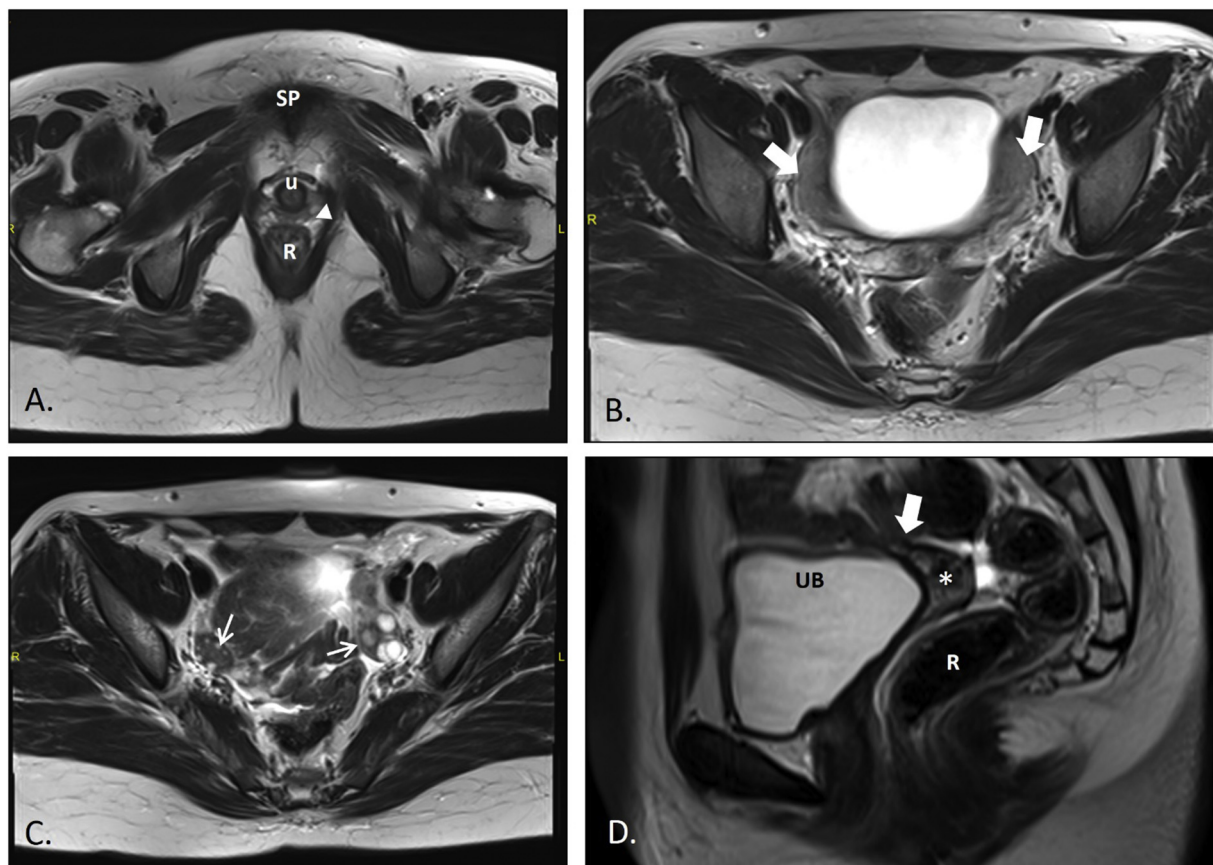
MRI of pelvis T2-weighted TSE images: Axial (A; at the level of symphysis pubis, B & C; at lower sacrum), and Mid-sagittal (D) showing absent cervix with interposition of bowel loops in the expected location of cervix (thick arrow in B). Rudimentary uteri (thick arrow in B) are interconnected at midline. The lower vagina is small (arrowhead in A). The vaginal vault is present (asterix in D). Both ovaries are normal (thin arrows in B). R: Rectum. SP: symphysis pubis. TSE: turbo spin echo U: urethra. UB: urinary bladder.
